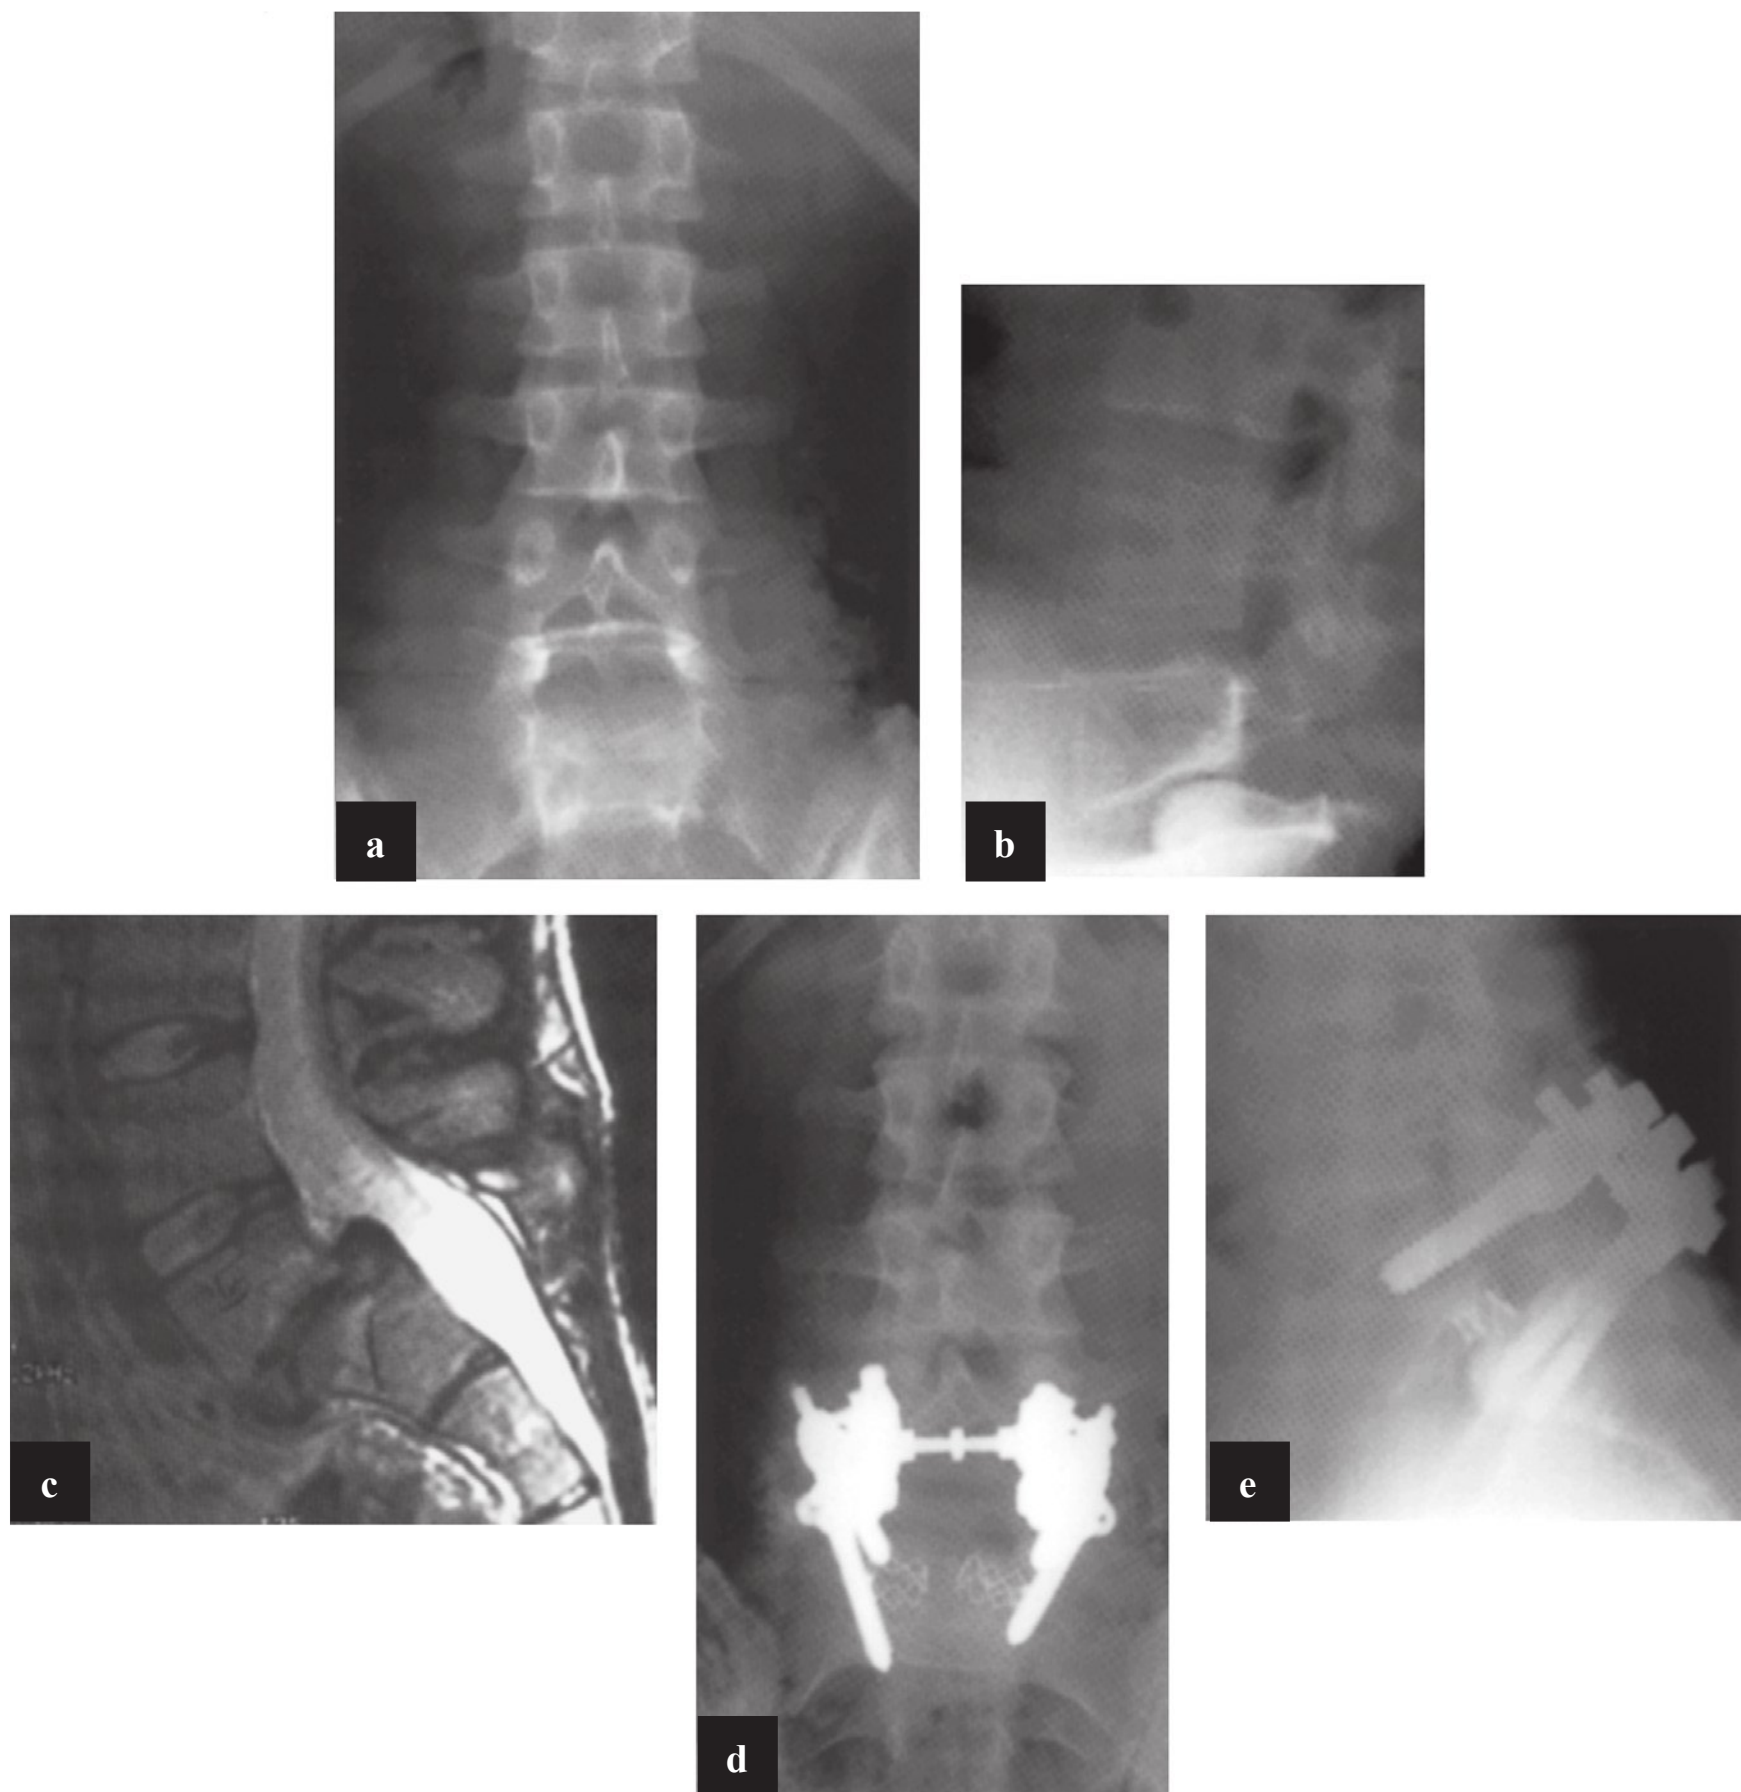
Images of an 18-year-old man with a high-grade L5–S1 isthmic spondylolisthesis and bilateral L5 radiculopathy. (a) Anteroposterior radiograph showing that the L5 transverse processes overlie the sacrum due to the severe slip. (b) Lateral radiograph showing the grade 3 slip. (c) Magnetic resonance imaging scan shows typical changes at L5–S1 rounding of the sacral dome. (d,e) Postoperative radiographs demonstrating the placement of interbody cages to increase the fusion rate with supplementary pedicle screw fixation.
